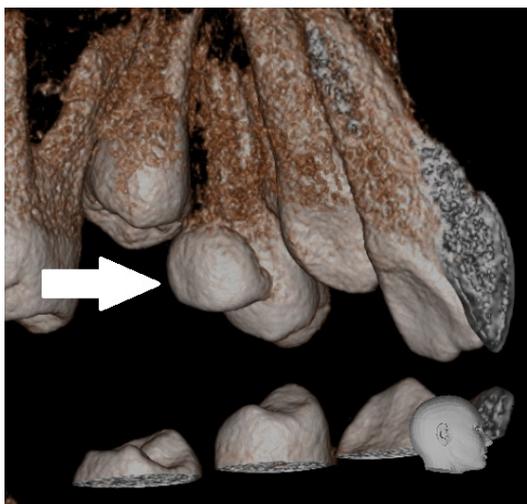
The reconstructed 3D CBCT image of the related area in sagittal plane (The abnormal structure was shown with a white arrow). The crown of the structure was similar with a maxillary primary first molar.
